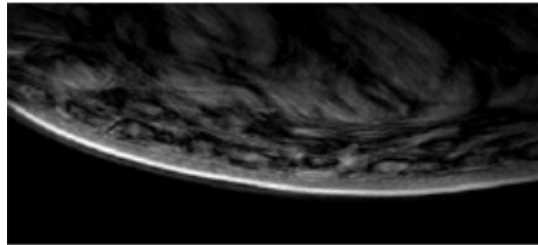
MRI sequence: Fast Field Echo
